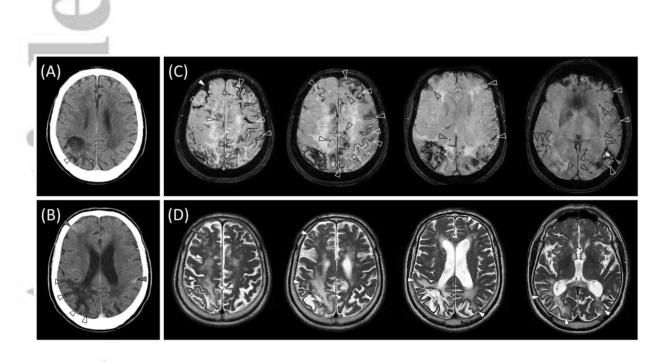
Imaging of Case 1. Minimal surrounding hypodensity on cranial computed tomography after regression of the first right parietal ICH (arrowheads), 6 years before presentation (A). Extensive hypodensity surrounding the site of prior ICH (hollow arrowheads) with a right frontal and a left parietal cSAH (grey-filled arrowheads, B). Multiple CMBs and diffuse CSS (a few examples marked with black and white hollow arrowheads respectively) with subacute cSAHs and ICHs (examples marked with a white-filled and a grey-filled arrowhead, respectively) on SWI (C). Asymmetric confluent WMHs reaching the immediate subcortex in each lobe of the right hemisphere and in the left frontal and parietal-occipital areas, consistent with probable CAA-RI (white-filled arrowheads, D). The right frontal 'SNN' (grey-filled arrowhead in D) is consistent with a cSAH (white-filled arrowhead in C).
